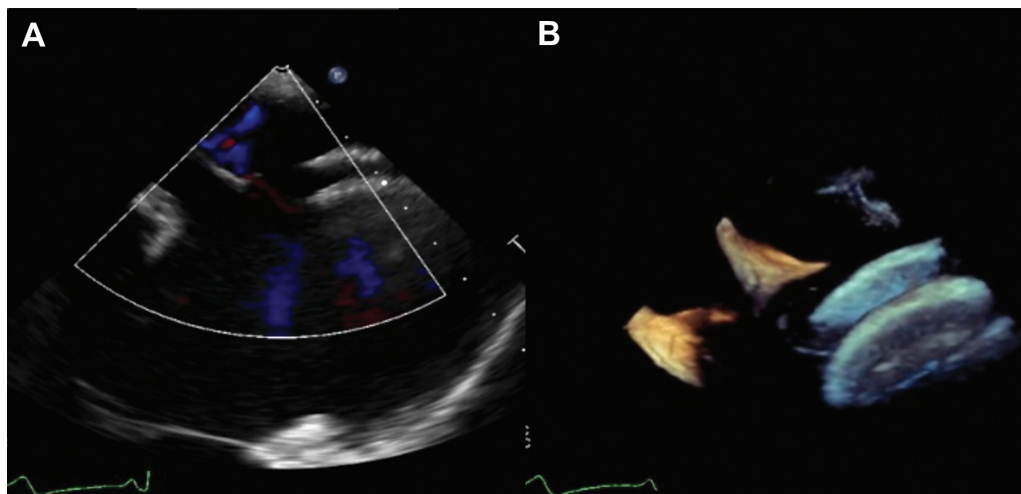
Preoperative echocardiographic images showing a significant interatrial shunt (A) and the presence of a single occluder (B).
